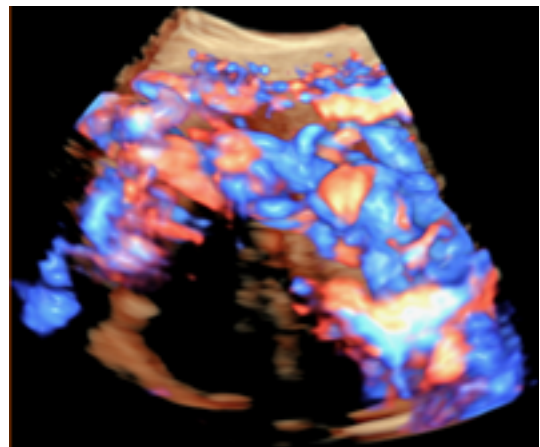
Ultrasound image of placenta accrete spectrum using three-dimensional (3D) high definition-flow with radiant flow method.
